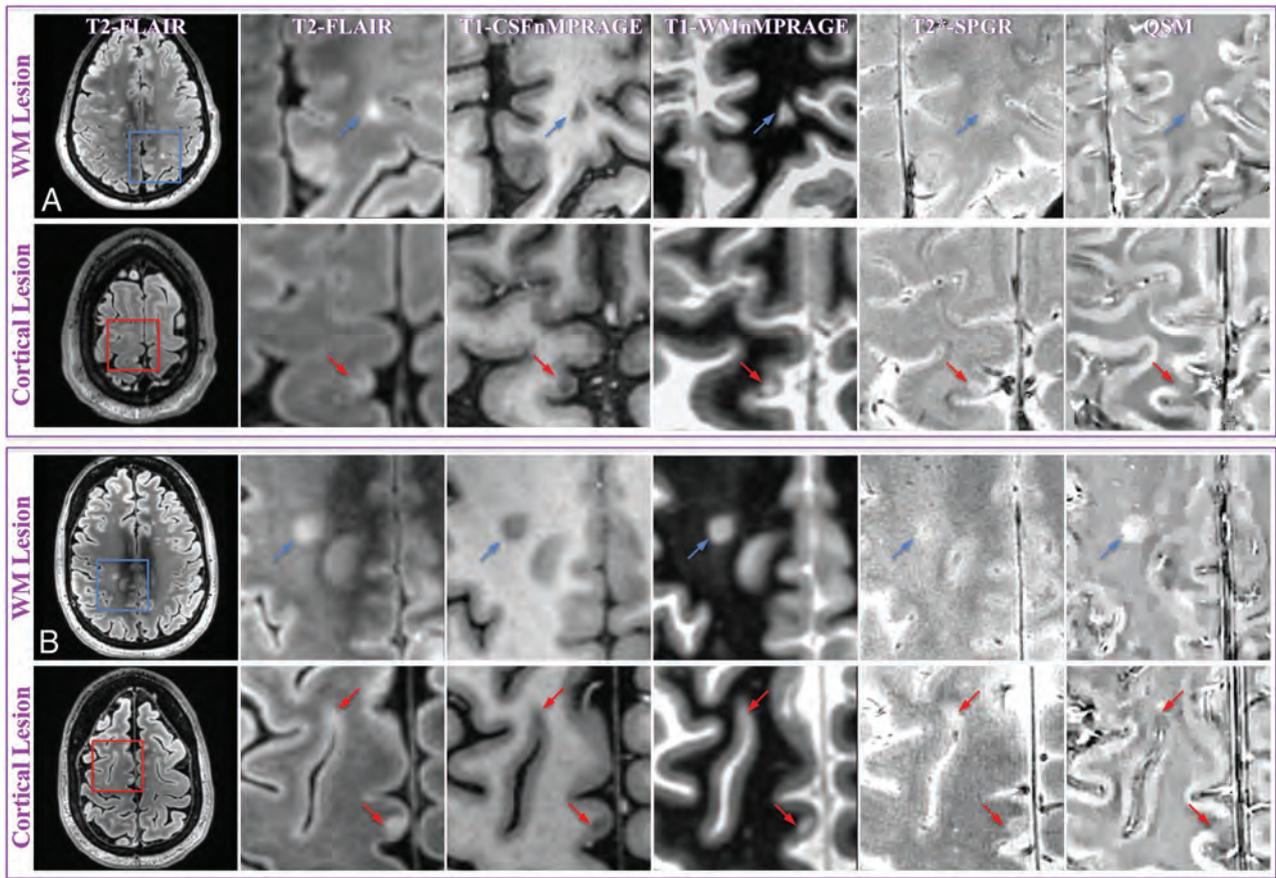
MR images of representative WM and cortical lesions from patients 4 (A) and 5 (B). A whole section of the T2-MPFLAIR image is displayed on the left column with a zoomed-in region (*blue/red square*) for all image contrasts. Two WM lesions (*blue arrows*) and 3 cortical lesions (*red arrows*) are shown. WM and cortical lesions are hyper- and hypointense relative to their adjacent parenchyma on QSM images, respectively, while both types of lesions show an identical contrast on all other images. CSFnMPRAGE indicates CSF-nulled MP RAGE; WMnMPRAGE, WM-nulled MP RAGE.
